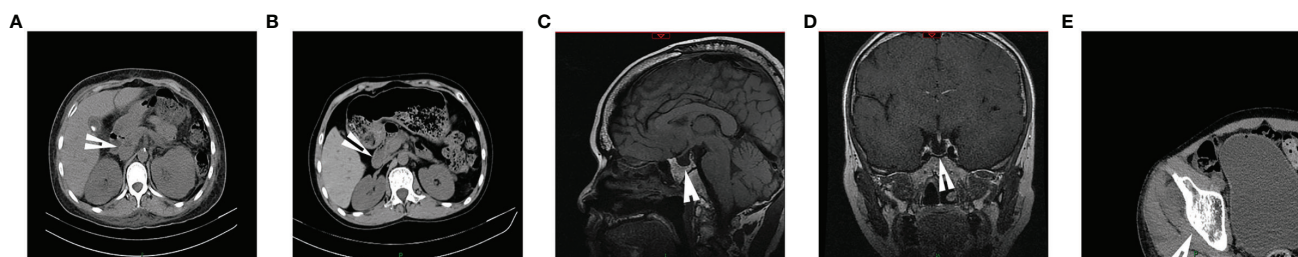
The images of the WSS patients. (A) Computed tomography of the abdomen of the proband demonstrated atrophy of the pancreas. (B) Computed tomography of the abdomen of the brother of proband showed uneven pancreatic density. (C, D) Pituitary MR of the brother of proband indicated the empty sella and none pituitary gland. (E) Hip CT of the brother of proband suggested osteoporosis that was not consistent with actual age. (arrows).
